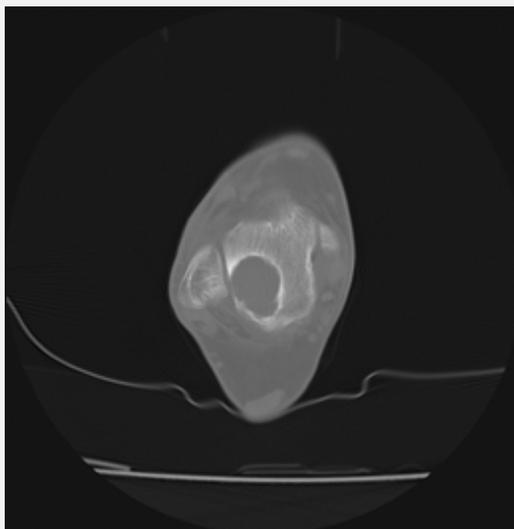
CT scan of the ankle showing a cystic image in the body of the talus with sclerotic edges and a thinned peroneal cortex.
